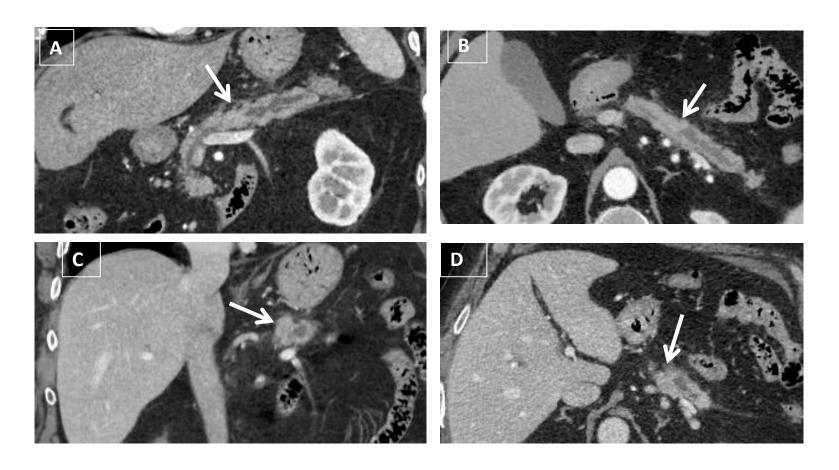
<u>Patient 1</u>. Contrast enhanced CT acquired 5 months later, oblique MPR (A,B), axial and coronal images. Note Increased segmental dilation of MPD compared to the first CT. There is an isodense mass (arrow) at the point of the stenosis. The mass deforms the contour of the gland on the postero-superior side of the body (C-D).
